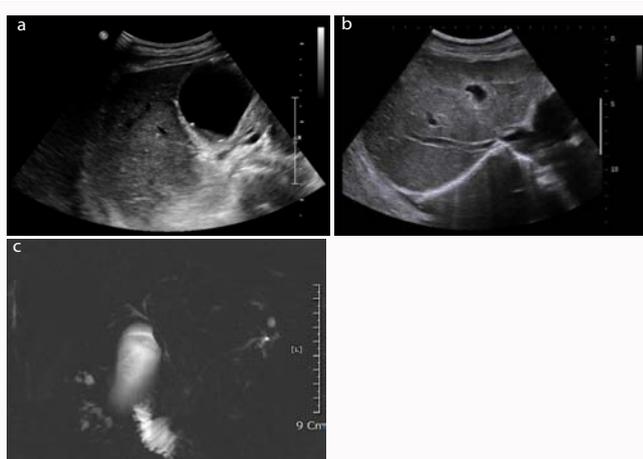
Imaging study of the patient. (A) Ultrasonographic image shows bile sludge and small gallstones in gallbladder without gallbladder wall thickening. (B) It also shows heterogeneously increased hepatic parenchymal echogenicity and no signs of chronic liver disease. (C) Magnetic resonance cholangiogram shows no obstructive lesion or duct dilatation in common bile duct.
